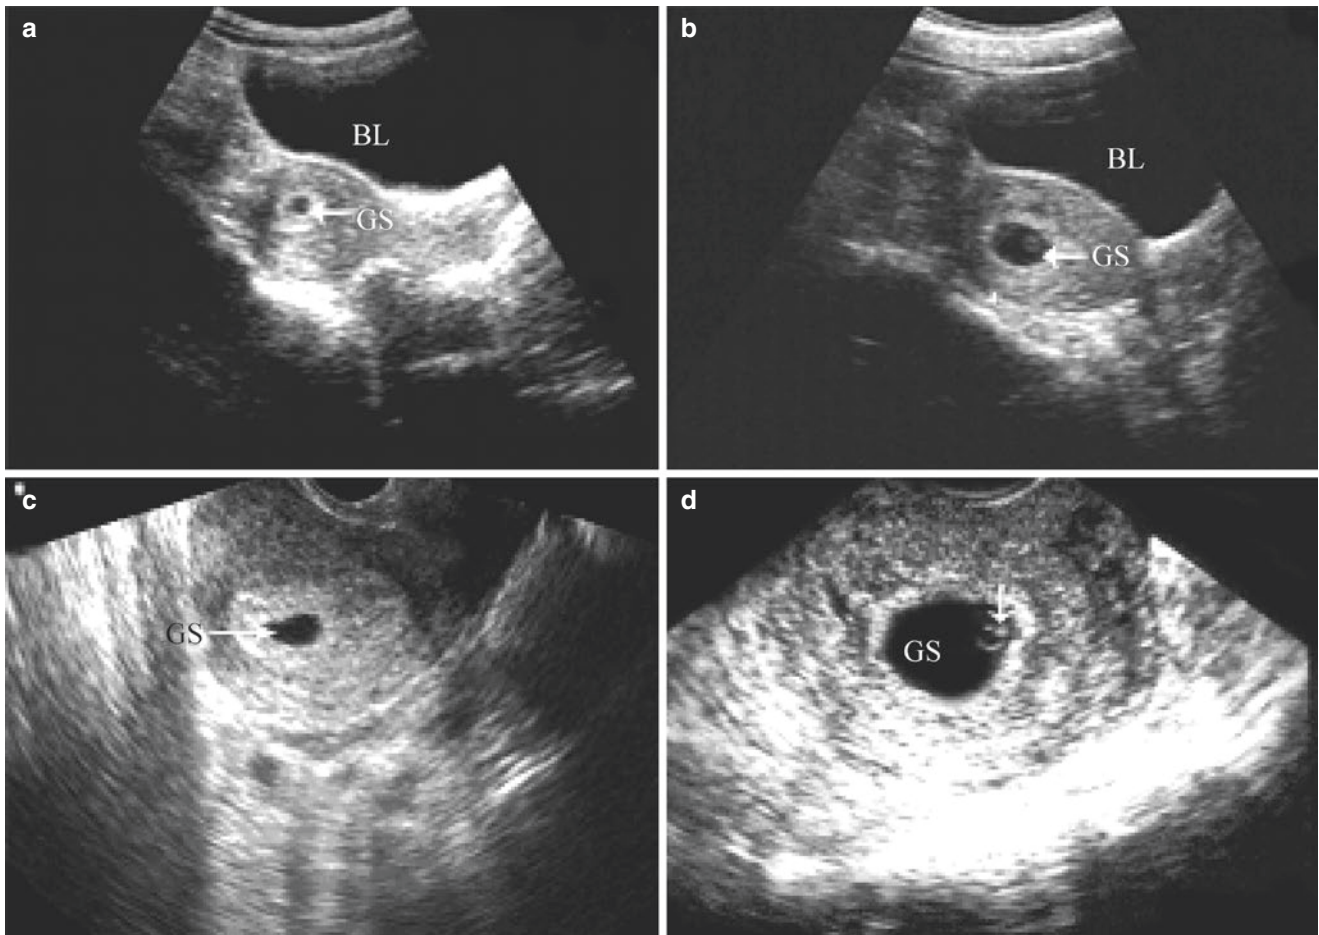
Transabdominal/transvaginal ultrasound images in early pregnancy. (a). Transabdominal scan, a tiny intrauterine gestational sac on day 38 of gestation; (b). Swollen uterus and an intrauterine gestational
